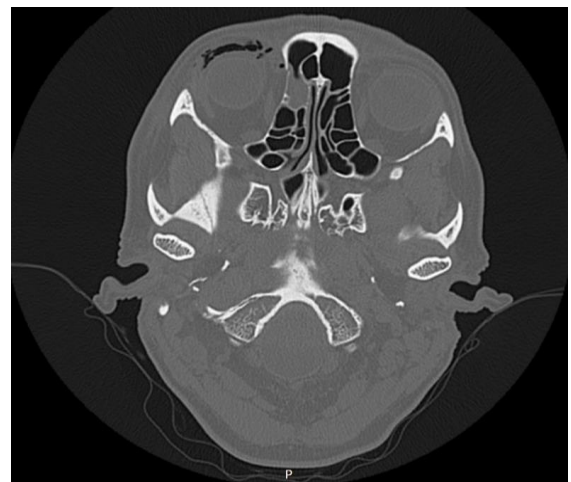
Axial view of the CT bone window showing right sided periorbital air.
